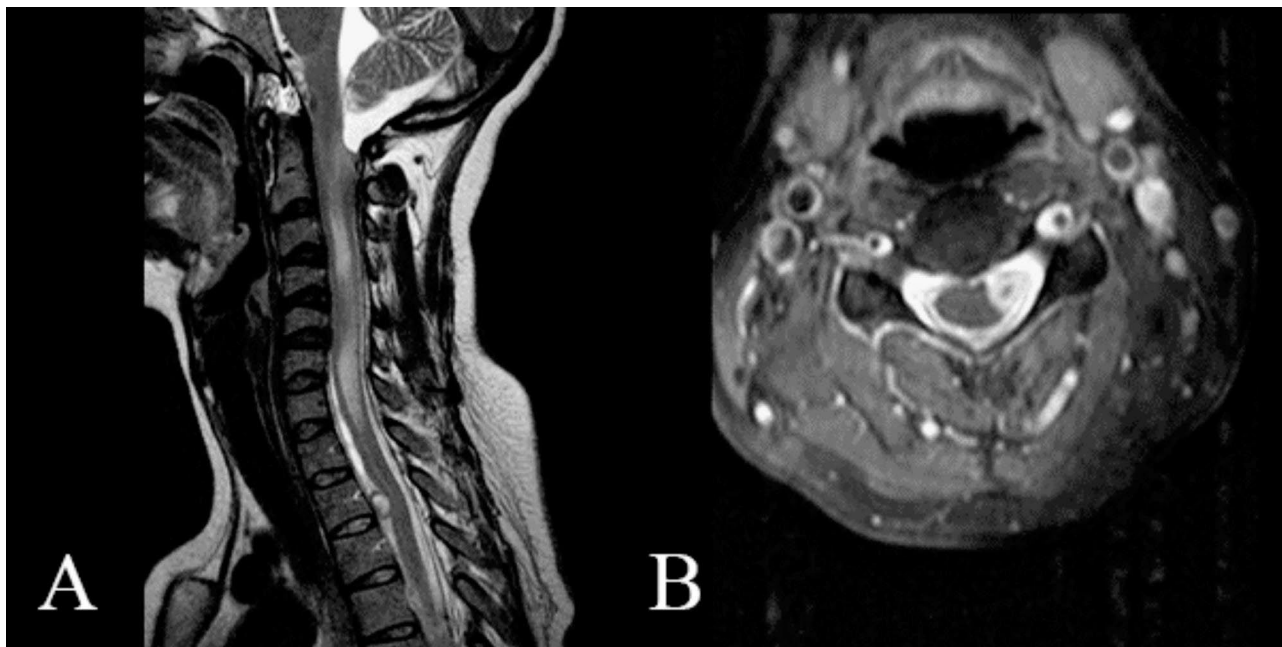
Spinal cord MRI. (A) There is dural thickening with extensive spinal cord T2 hyperintensity, absence of the normal CSF column with enlargement of the cisterna magna, and an intradural oval image with peripheral T2 hypointensity and gadolinium enhancement in the topography of the C3-C4 intervertebral disc, measuring about 7.3×4.6 mm. (B) Axial image of the cervical spine showing diffuse circumferential pachymeningeal enhancement and an oval intradural image, with peripheral contrast-enhancement, measuring about 12.0×8.0 mm, on the topography of the intervertebral disc T2-T3
